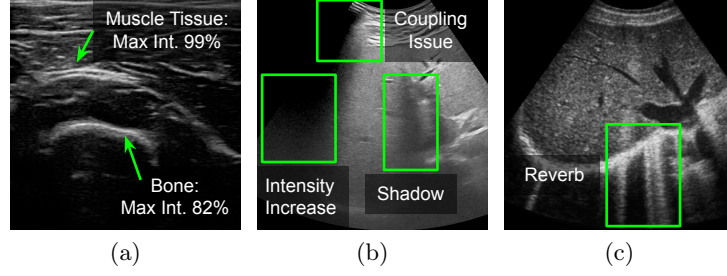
Complex relationship between confidence and pixel intensities. (a): tissue that blocks sound (bone) causing a weaker signal than a tissue that doesn’t block sound (muscle). (b-c): different common ultrasound artifacts.
